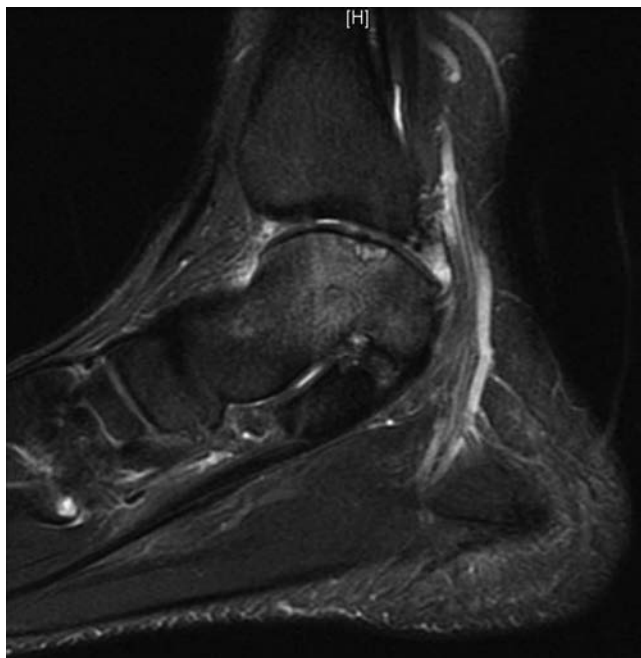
MRI osteochondral defect (OCD) sag.
